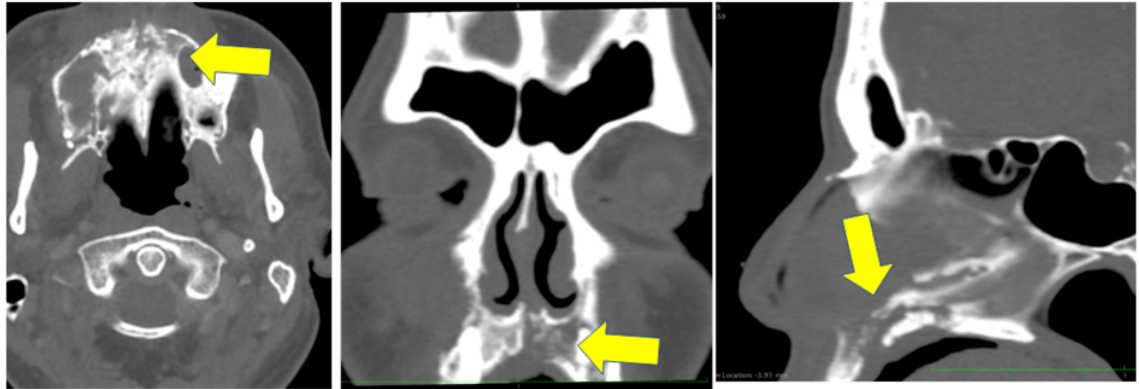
a/b/c. Bone infiltration by Mucormycosis. Axial CT shows erosion of floor of left maxillary sinus with involvement of hard palate; the erosion and destruction of hard palate can be seen on coronal and sagittal reconstructed MDCT images.
